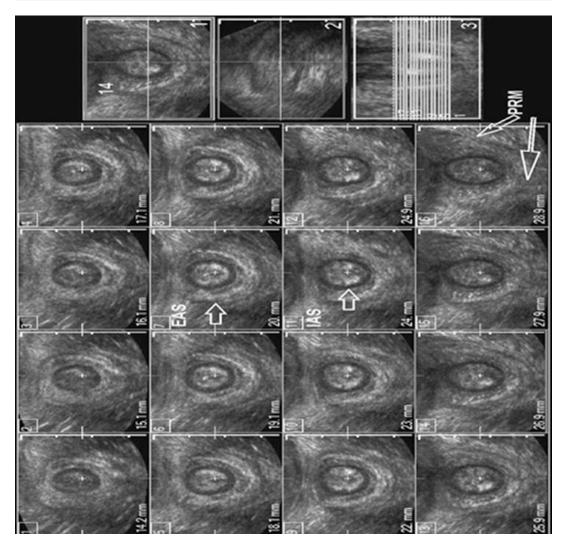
3D perineal ultrasound of the anal canal with 1 mm slices from the anal verge to the anorectal angle. Internal anal sphincter (IAS), external anal sphincter (EAS), and posterior portion of the puborectalis muscle shown
